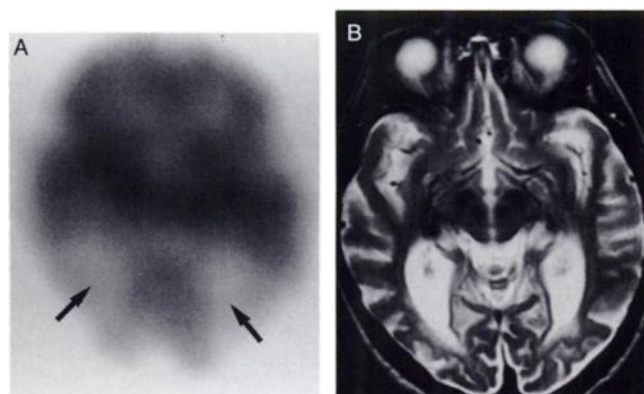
SPECT and MRI of Patient 7, whose visual agnosia was caused by Alzheimer's Disease. (A) SPECT reveals hypoperfusion most markedly in occipitoparietal regions bilaterally (arrows). (B) MRI shows only cerebral atrophy.
